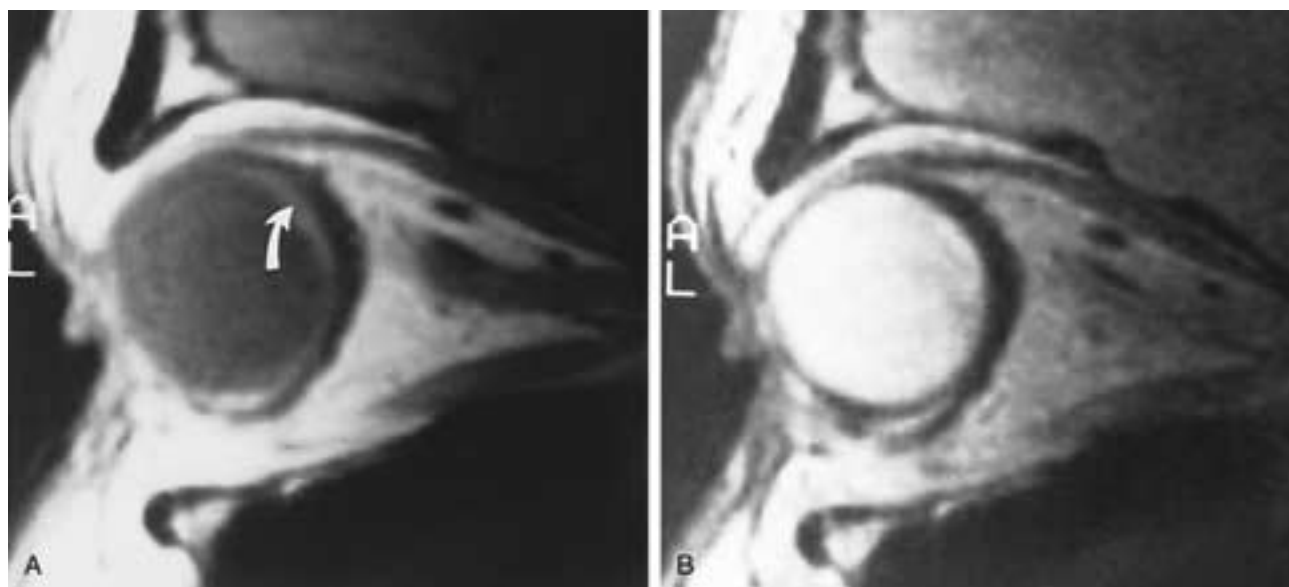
Choroidal hemangioma. A, Sagittal PW MR image shows a hyperintense mass (arrow). B, Sagittal T2-weighted MR image shows that the mass remains hyperintense. Ophthalmoscopic findings were most compatible with hemangioma. This MR imaging appearance may be difficult to differentiate from retinal detachment. Combined clinical and MR imaging findings should help the clinician make the right diagnosis.
